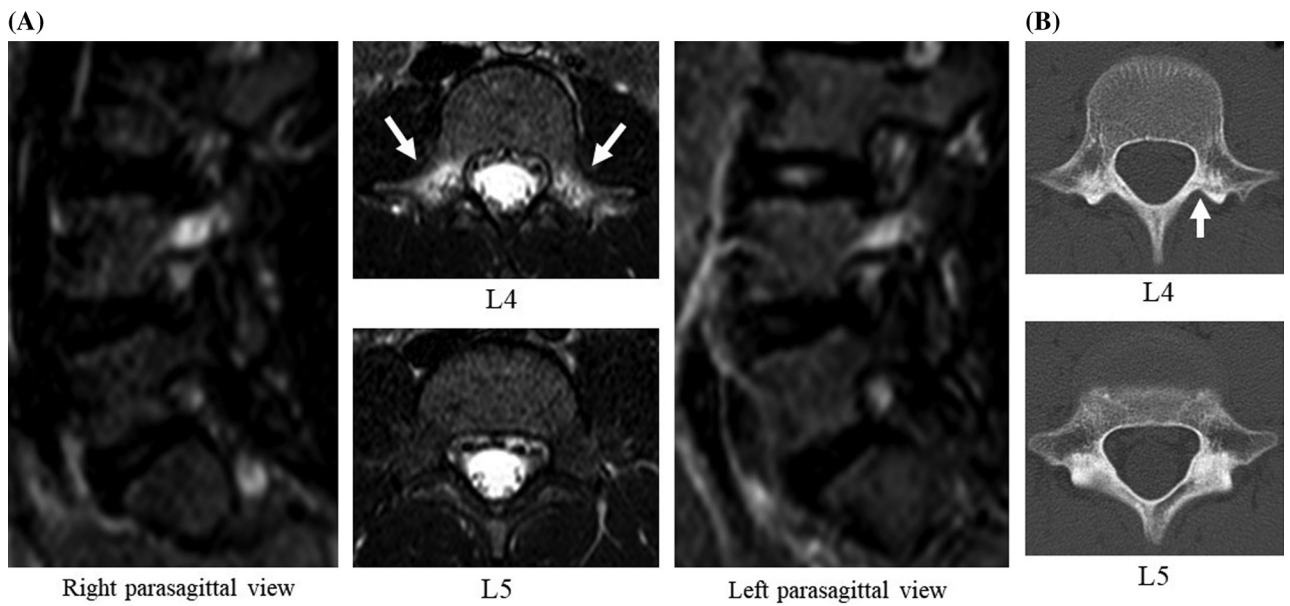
(A) Magnetic resonance images showing a high signal intensity change at the L4 pedicles bilaterally (indicated by arrows). (B) CT scans showing a faint fracture line (arrow) at the L4 pars on the left with no findings at L5. CT: computed tomography.
